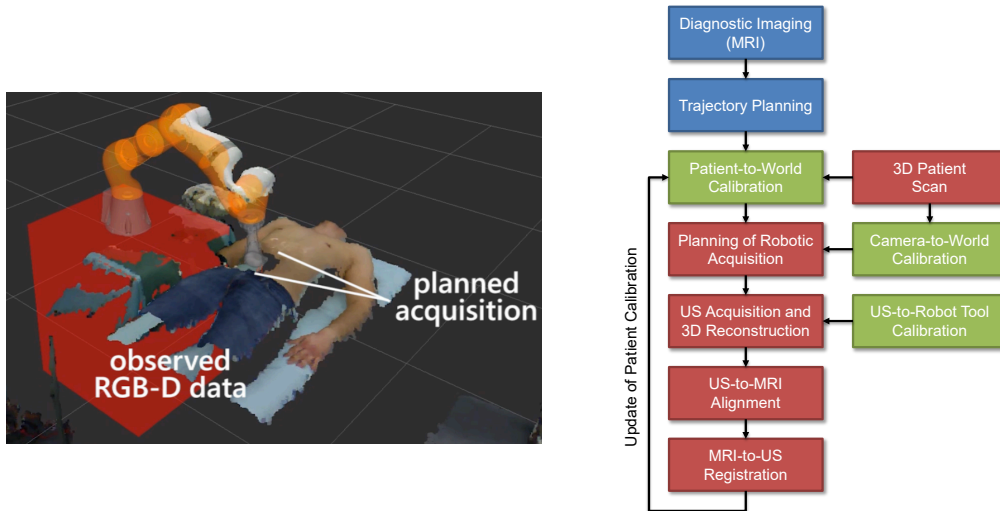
Left: Robot kinematics and external 3D sensing information are fused in a common reference frame and visualized in a 3D environment. It is possible to notice the current patient location with respect to the manipulator. The acquisition planned using a pre-operative volume is transfer to the same environment by point-set registration. Right: The proposed workflow for autonomous robotic ultrasound acquisitions. It includes planning steps based on pre-operative diagnostic images (blue), a series of calibration between external camera to robot and robot to patient (green), and the actual acquisition and calibration refinement steps (red).
